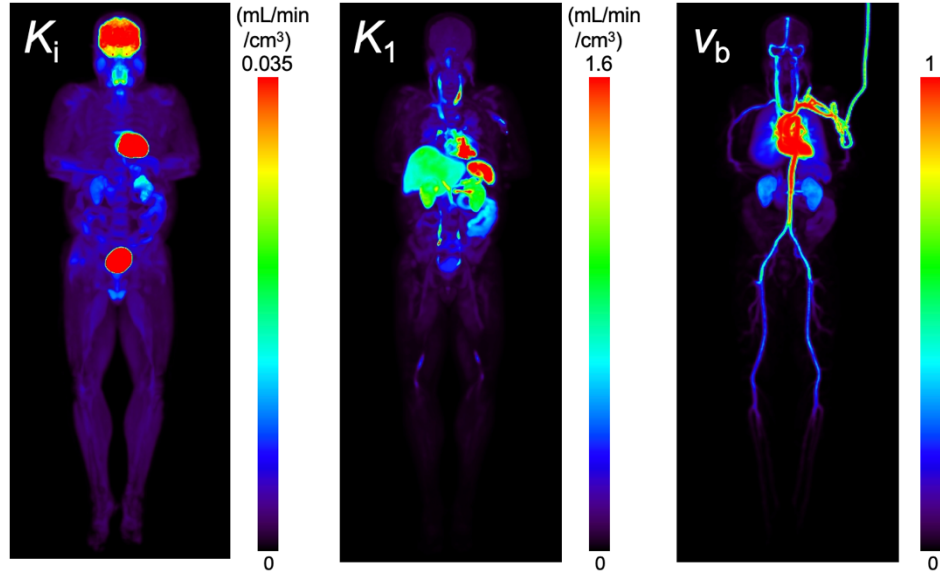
Multiparametric images of ^{18}F -FDG net influx rate K_i , ^{18}F -FDG delivery rate K_1 , and fractional blood volume v_b . The images are maximum intensity projections.
